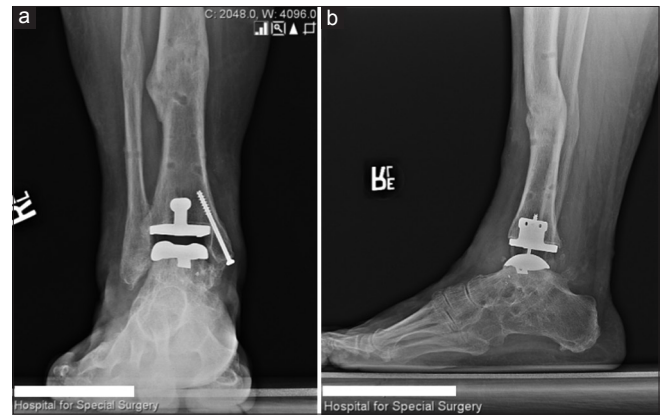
Weight-bearing (a) anteroposterior and (b) lateral radiographs 7 weeks following removal of the Taylor Spatial Frame. The healing tibial and fibular osteotomy sites are seen with normalized alignment of the total ankle replacement and complete resolution of subfibular impingement
